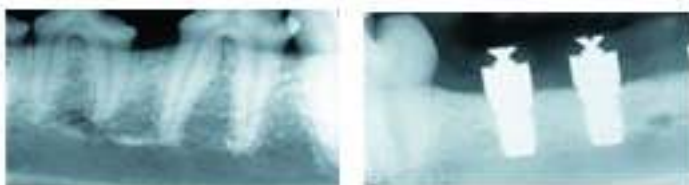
(Left) Radiograph obtained from the premolars in the left side of the mandible.³ (Right) Radiograph obtained from the implants in the right side of the mandible.³
